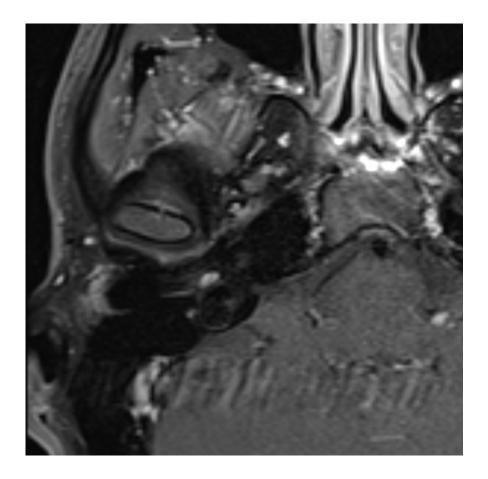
T2 MRI sagittal view showing tiny nodular lesion about 3 mm in diameter, within the inferolateral aspect of right middle ear cleft overlying the dome of the right internal jugular vein, showing intense postcontrast enhancement.
